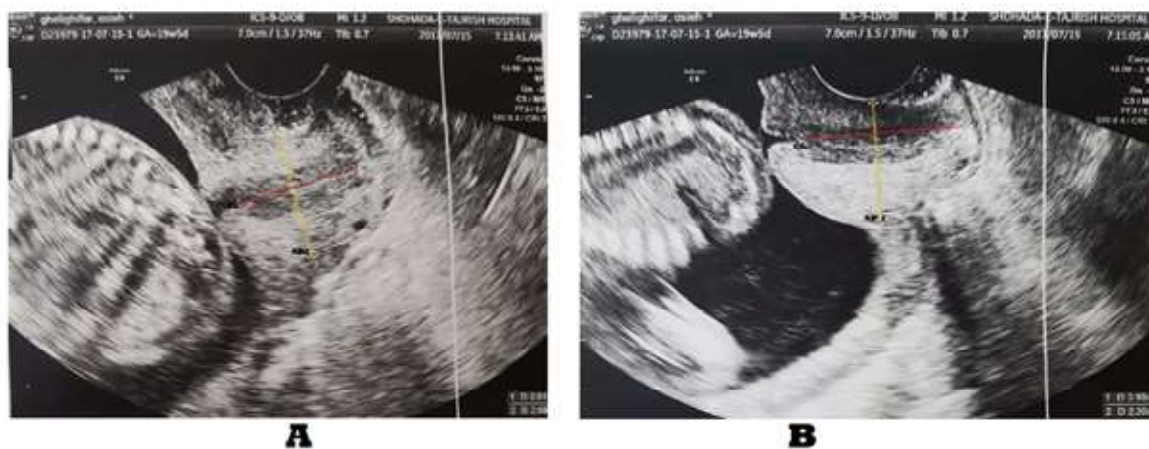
Ultrasound image of cervix before (A) and after maximal compression with probe (B). The anteroposterior diameters (AP1, AP2) and cervical length (CL1, CL2) were measured in each position. The CCI index was determined from $\text{AP2}/\text{AP1} \times 100$ for each participant
